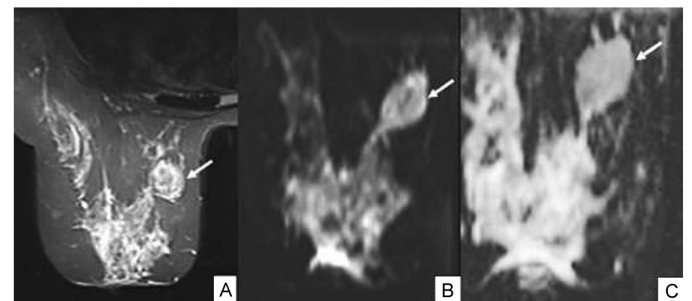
Contrast-enhanced axial image (A), DWI (B), and ADC map (C) of a malignant lesion (DIS). Apparent diffusion coefficient value of the lesion at B1000 is 143×10^{-6} . ADC, apparent diffusion coefficient; DIS, I added wrong figures, I need to delete and the rights. dissemination in space; DWI, diffusion-weighted imaging.
